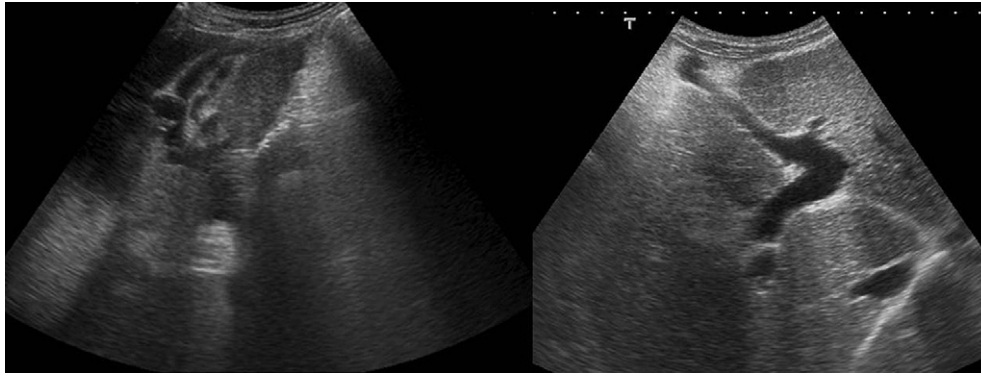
Ultrasound image of a patient with portal hypertension showing recanalized umbilical vein.
